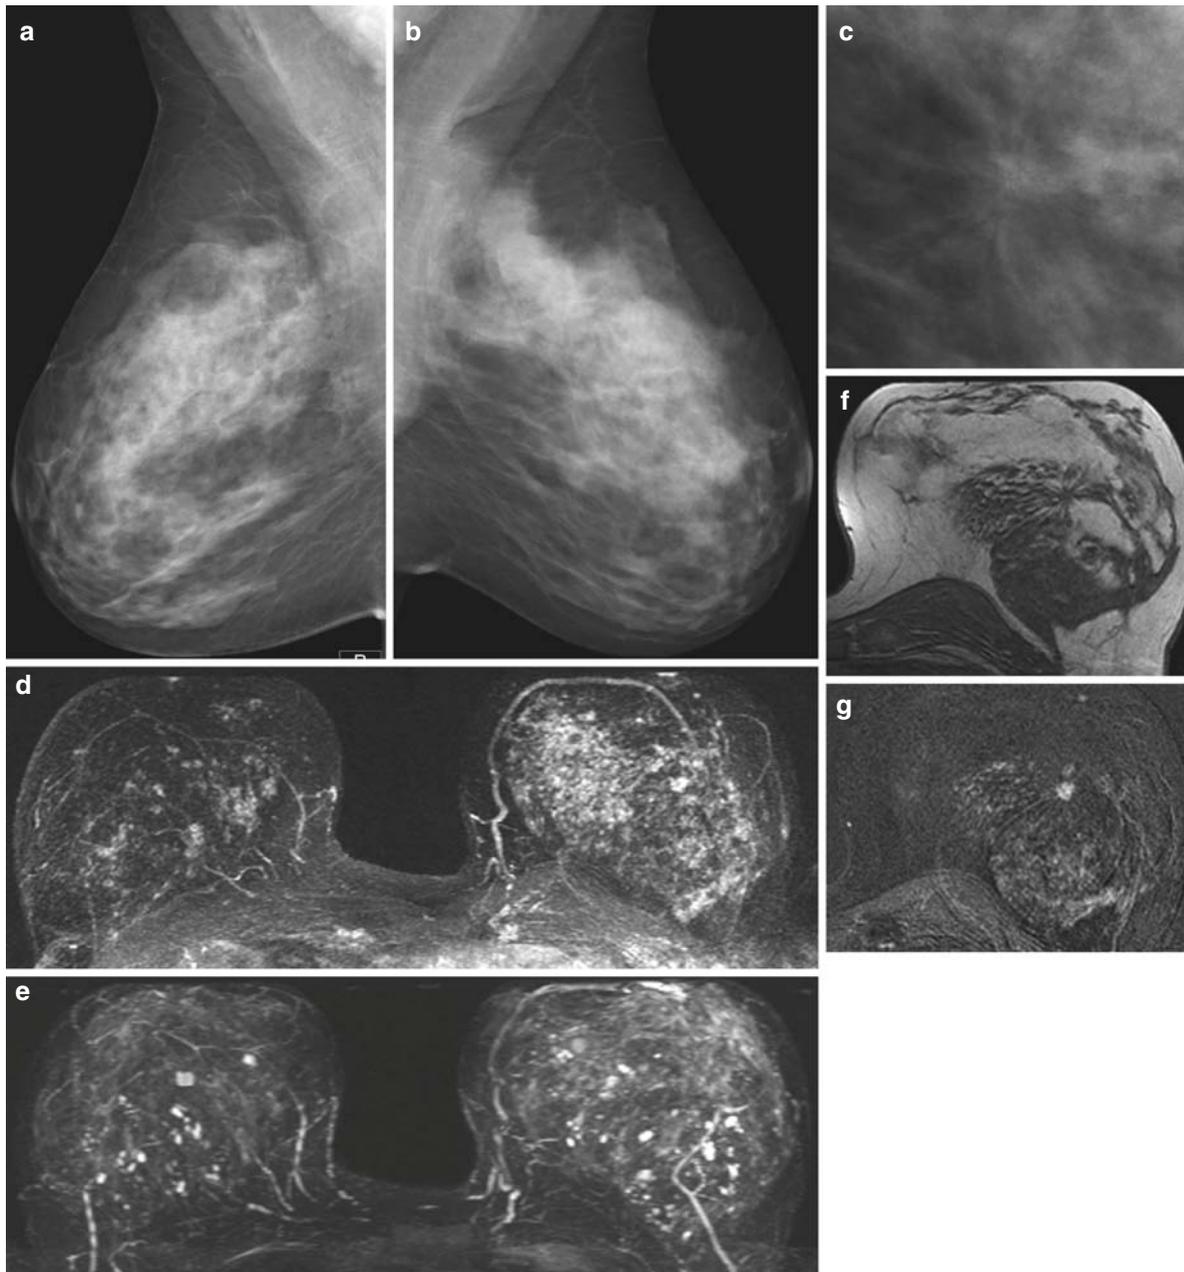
Radial scar with associated small breast cancer. Digital mammography in MLO projection (a, b). Density type ACR IV. Architectural distortion in the center of the left breast (b), better seen on magnification mammogram (c). MRI demonstrates asymmetric uptake of the contrast material (left > right). Small hypervascularized nodule in the center of the left breast
